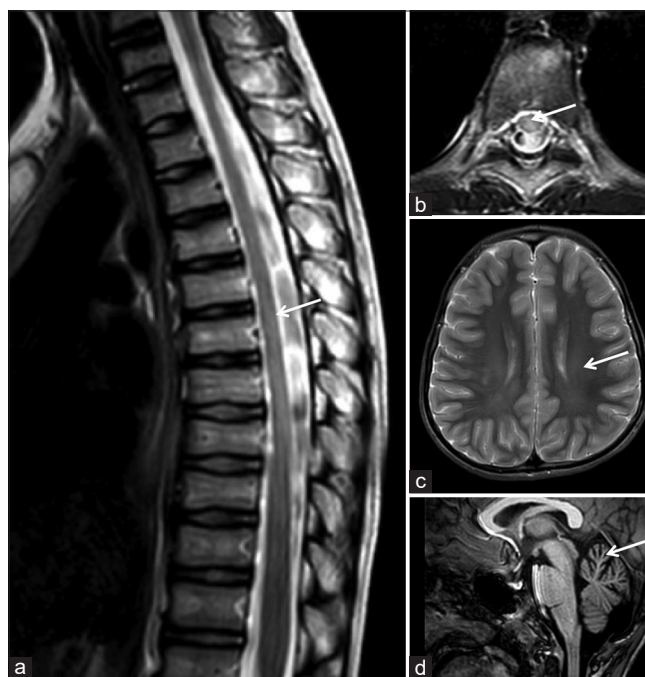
MRI spine and brain reveals diffuse ill-defined T2 hyperintense signal abnormality in the thoracic cord on T2 weighted sagittal (a) and axial (b) images. Diffuse subtle hyperintense signal is seen in the periventricular and deep white matter on T2 weighted axial images of the brain (c). Superior vermis volume loss is seen on mid-sagittal T1 weighted image (d)
